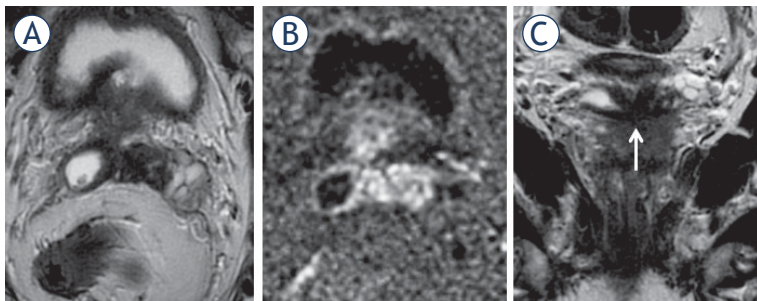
65-yr-old-man with PSA = 15.3 ng/ml and Gleason score 4 + 4 = 8 at biopsy. Axial (A) and coronal (C) T2 weighted imaging (T2WI) and diffusion weighted imaging (DWI) (B). T3b involving both seminal vesicles via ejaculatory ducts, shown in the coronal plane (arrow).
